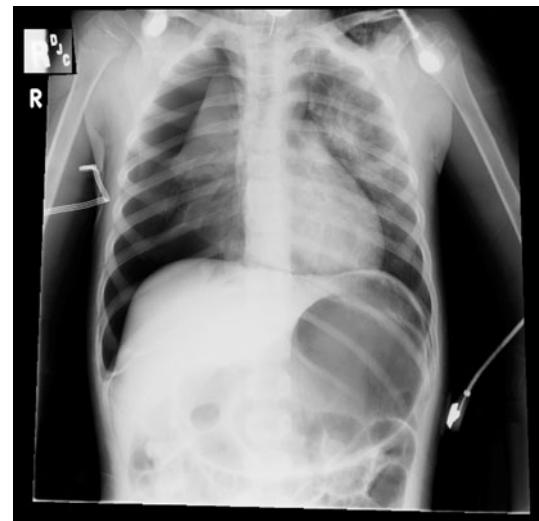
Chest radiograph of the chest showing tension pneumothorax on the *right side*
